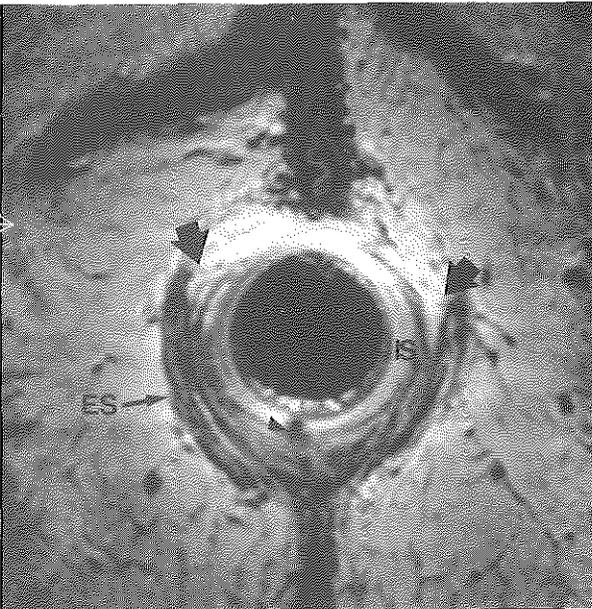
Endoanal MRI, axial proton density weighted GRE showing an external sphincter (ES) defect (arrows). Internal sphincter (IS). The patient presented with fecal incontinence after delivery. Small coil artifact (arrowhead).
